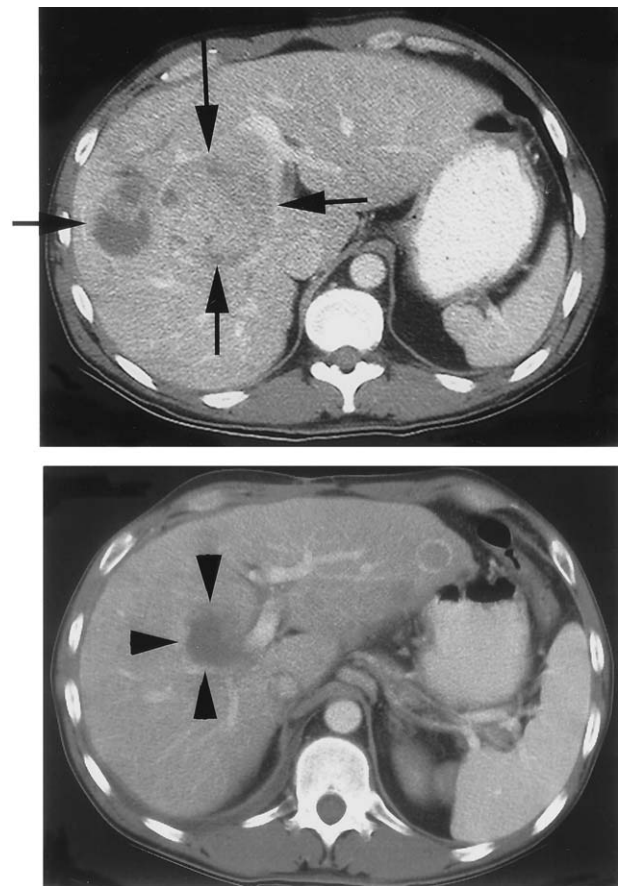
Pre- and post-treatment contrast-enhanced CT scans from a patient with unresectable HCC. The patient received a 60-minute IHP. The patient achieved a partial response to therapy for approximately 10 months with initial recurrence in lung and liver. *Top panel* demonstrates the appearance of representative lesion before treatment. *Bottom panel* represents a comparable tumor 5 months after treatment. *Arrows* delineate the extent of the tumor in the top panel; *arrowheads* depict it in the bottom panel.
